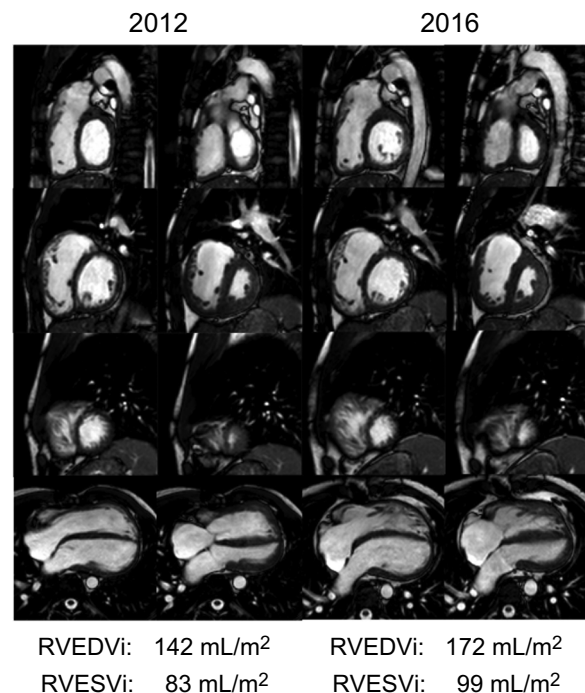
Progressive dilation of the right ventricle in a patient after repaired tetralogy of Fallot and pulmonary insufficiency demonstrated by cardiac magnetic resonance imaging. Short axis stack (basal, upper row; midventricular, second row; apical, third row) and 4-chamber view (lower row) of cine steady-state free precession end-diastolic (first and third columns) and end-systolic (second and fourth columns) images of the same patient in 2012 and 2016. Note the progression of the dilation of the right ventricle. RVEDVi, right ventricle end-diastolic volume index; RVESVi, right ventricle end-systolic volume index.
